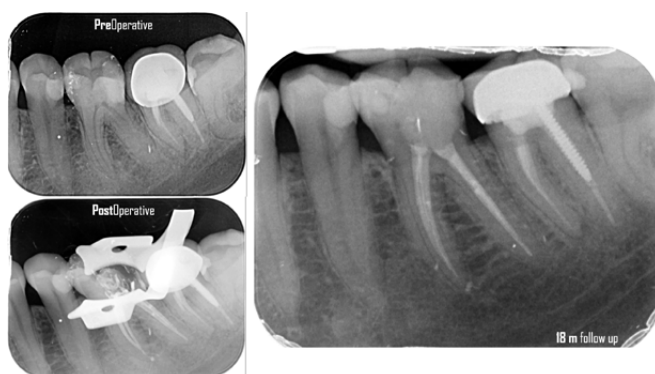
Preoperative, postoperative X-rays and 18 months follow up X-ray of tooth #36.
